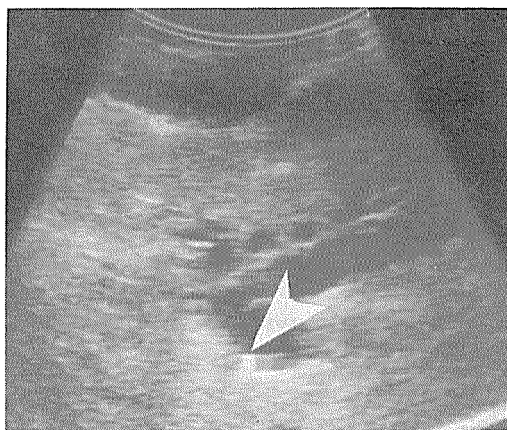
Catheter in the left hepatic duct. a) Ultrasonic feature. b) Radiologic feature.
